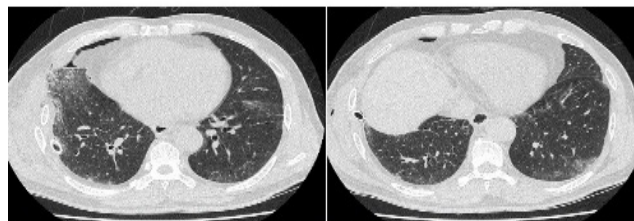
High-resolution computed tomography on admission. The multifocal ground glass opacity patterns of interstitial pulmonary lobules in both lung fields.
